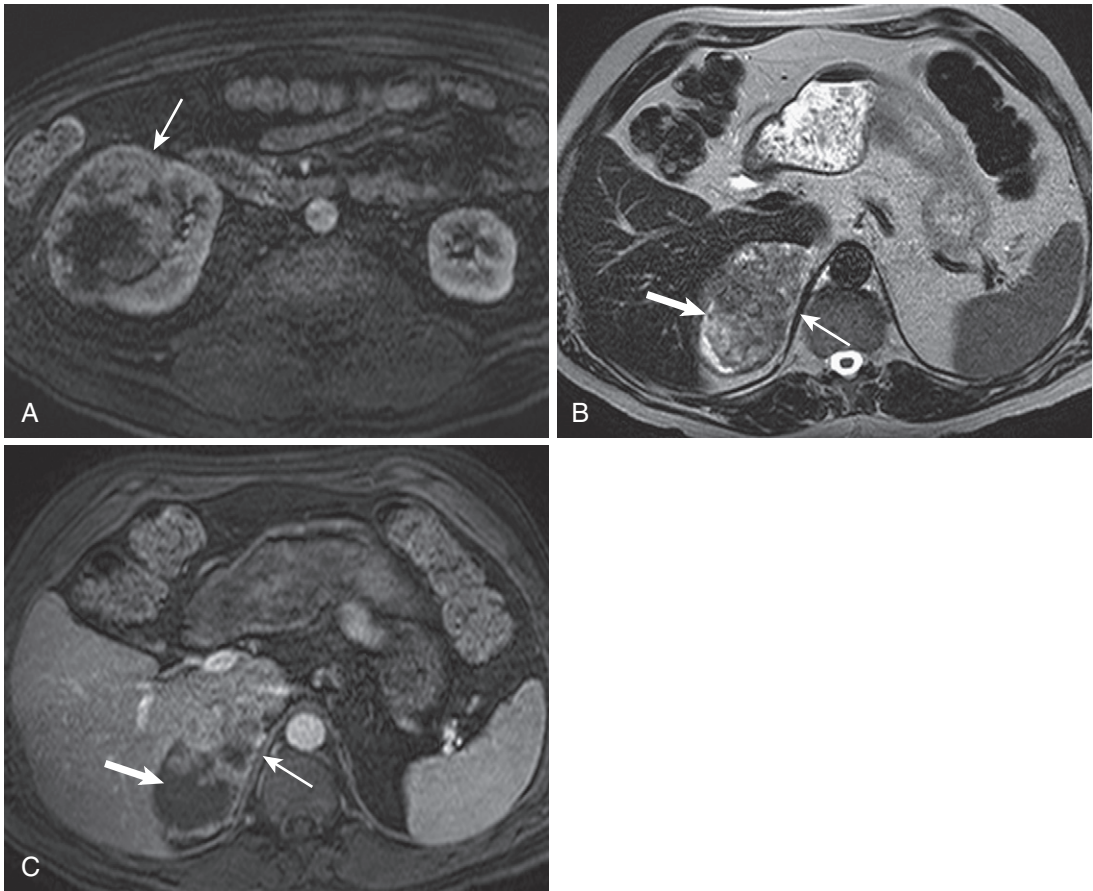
RCC with spread to other organs. A, The postcontrast image reveals a large heterogeneously enhancing mass in the right kidney (*arrow*), typical of a clear cell RCC. T2-weighted (B) and postcontrast (C) images at the superior extent of the mass (*thin arrow*) show extrarenal extension with neoplastic replacement of the right adrenal gland (*thick arrow*).
